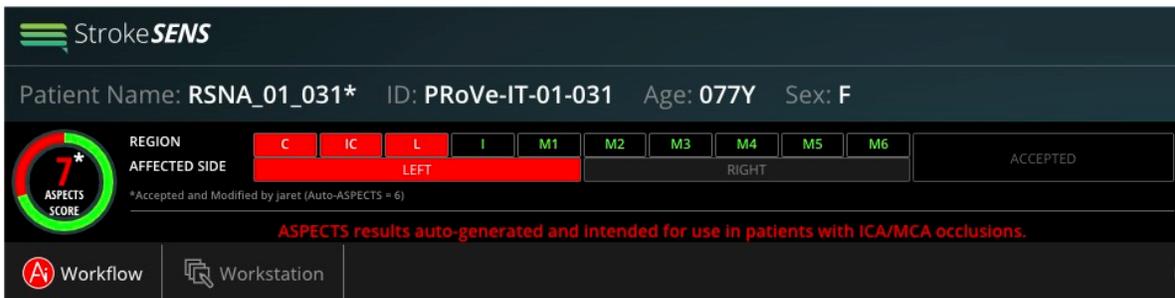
ASPECT score after clinician review and acceptance
